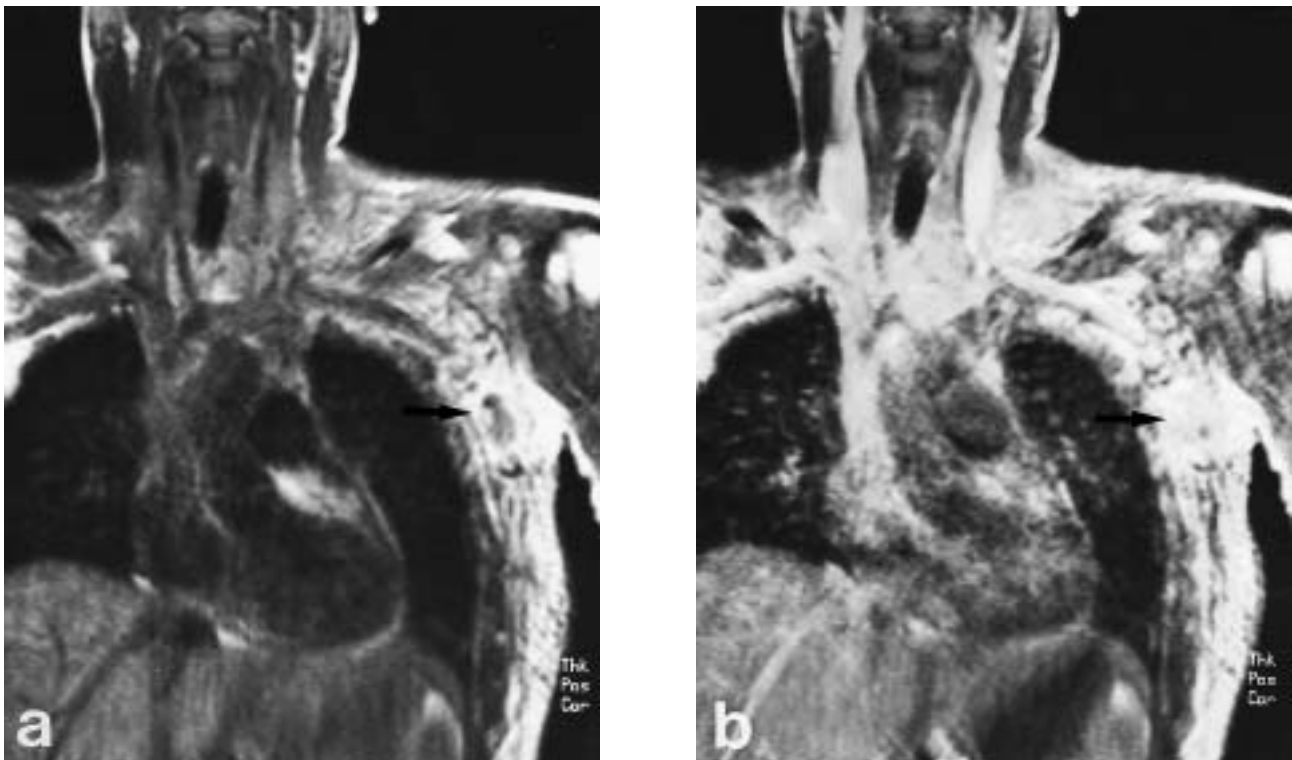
Magnetic resonance imaging of a severely ill patient with mediastinitis and extended soft tissue phlegmone spreading from an axillary abscess (arrows). Coronal T1-weighted a) pre and b) postcontrast images show intense and extended contrast enhancement within the cervical, chest wall, neck, and mediastinal soft tissue. Fast images, pre and postcontrast within 2.5 min.
